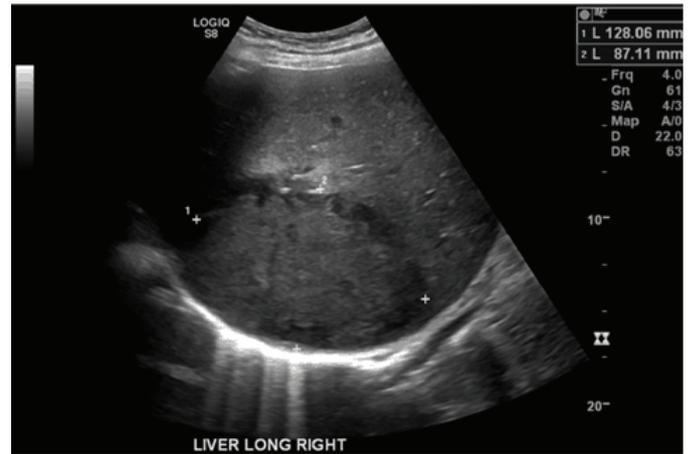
Ultrasound showing 13x11.2x8.7 cm focal lesion in the right lobe of liver at segment 7/8.
